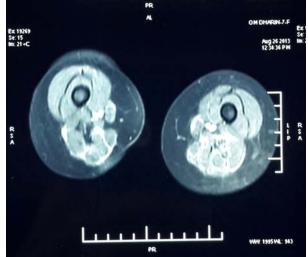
MRI of thighs showing ill-defined high signal in STIR sequences suggestive of muscle edema in both thighs and few low signal foci suggestive of calcifications.
